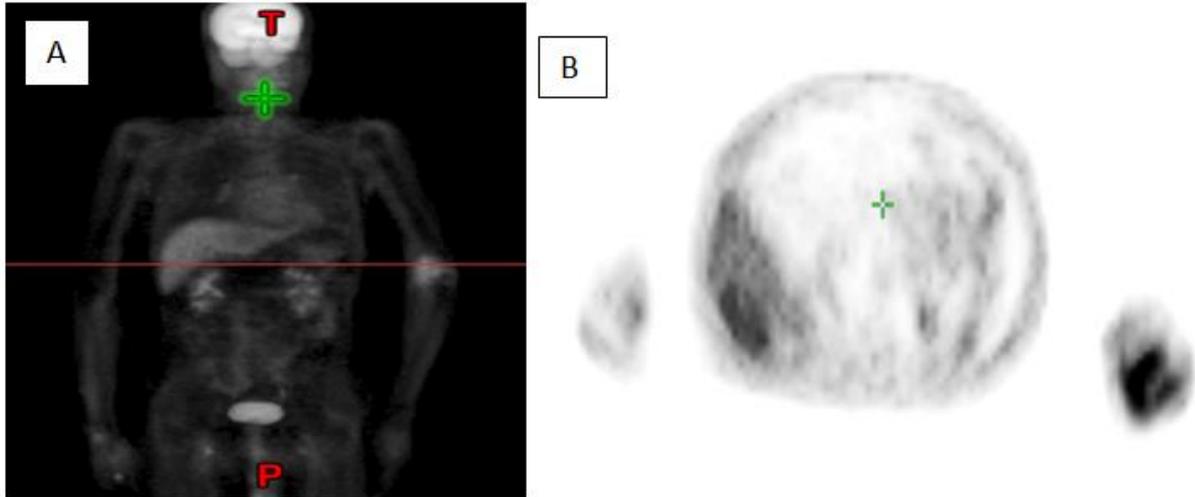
18 FDG positron emission tomography of our patient showing myeloid sarcoma at the left elbow; A: Whole body topogram. B: Axial image
